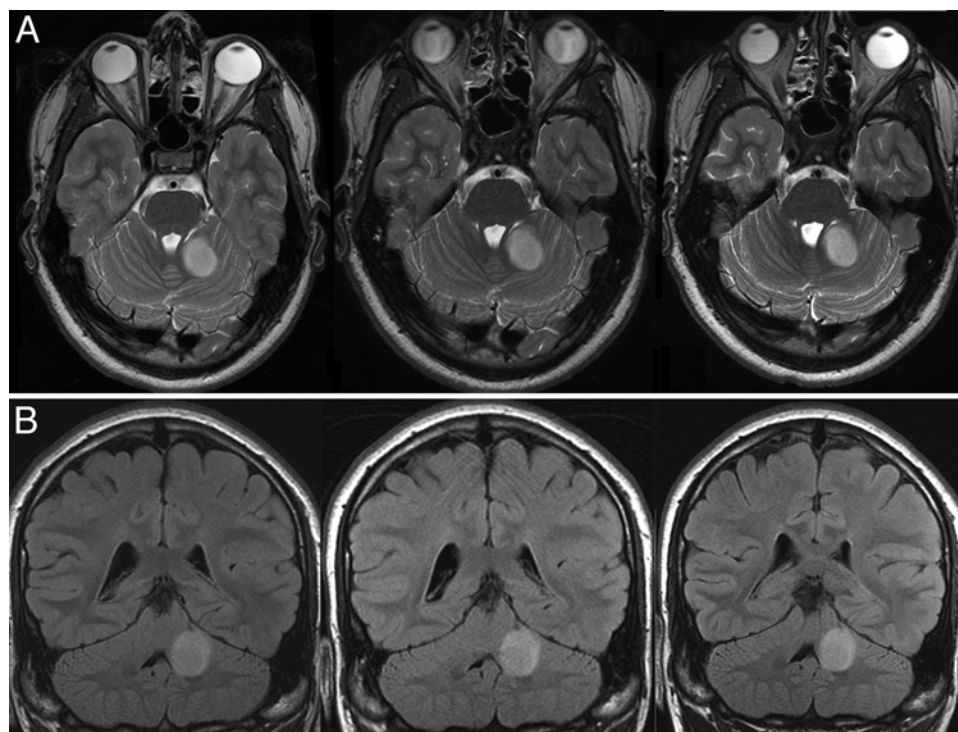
Case 2. Incidental cerebellar mass lesion (assumed diagnosis of LGG) found in a 14.9-year-old boy with anxiety disorder. Axial T2-weighted MR (A) and coronal FLAIR (B) images. Left panels were obtained initially. Center and right panels show the lesion after a period of 5 and 13 months, respectively, of wait-and-see.
